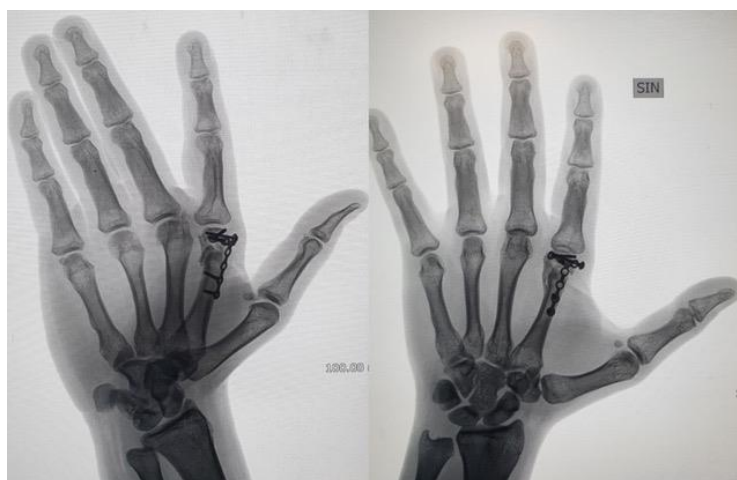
X-rays at 6-month follow-up.
